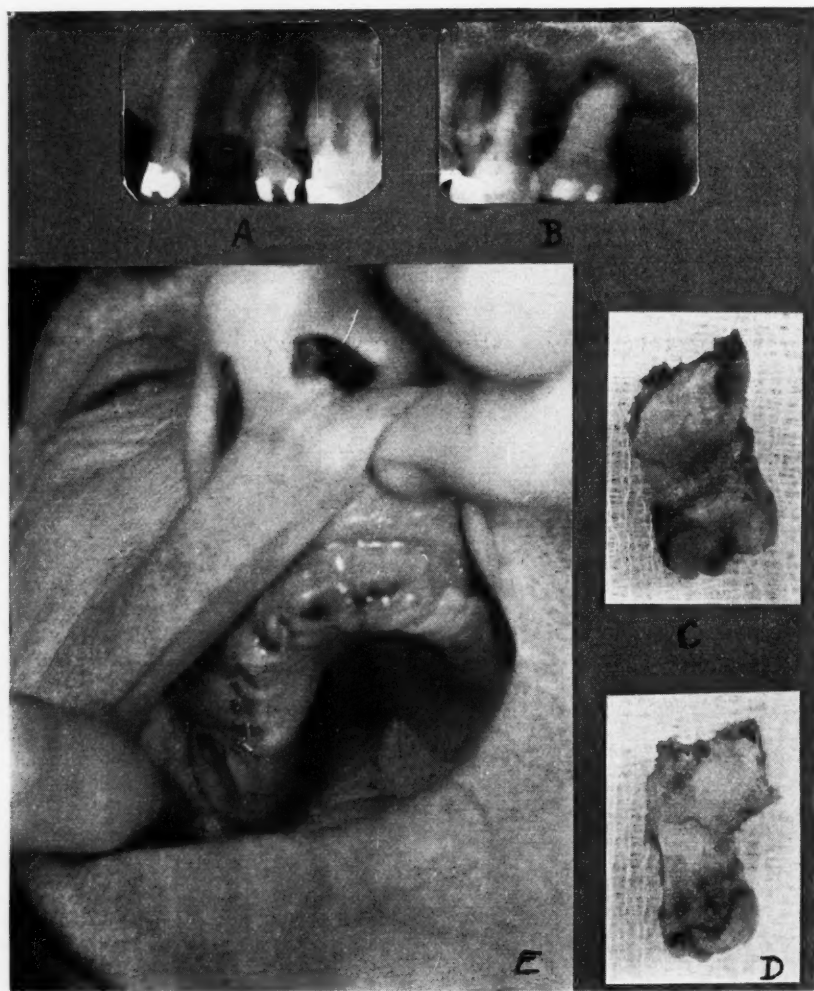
A and B, Lateral intraoral roentgenograms of right maxillary premolars and molars. The first premolar root shows questionable periapical bone condition. The second premolar does not show any definite pathologic change. The first and second molars show a deep periodontal osteitis and a questionably lessened density throughout the entire area, but there is no definite destruction of bone shown in the periapical areas. Upon operating this area, a definite chronic osteomyelitis was found extending from premolars to the tuberosity. C and D, Photographs of the molar teeth with the diseased chronic and inflammatory bone tissue attached to them. E, Photograph immediately after operation showing small opening in the last molar region left for the insertion of a wick and drainage.
